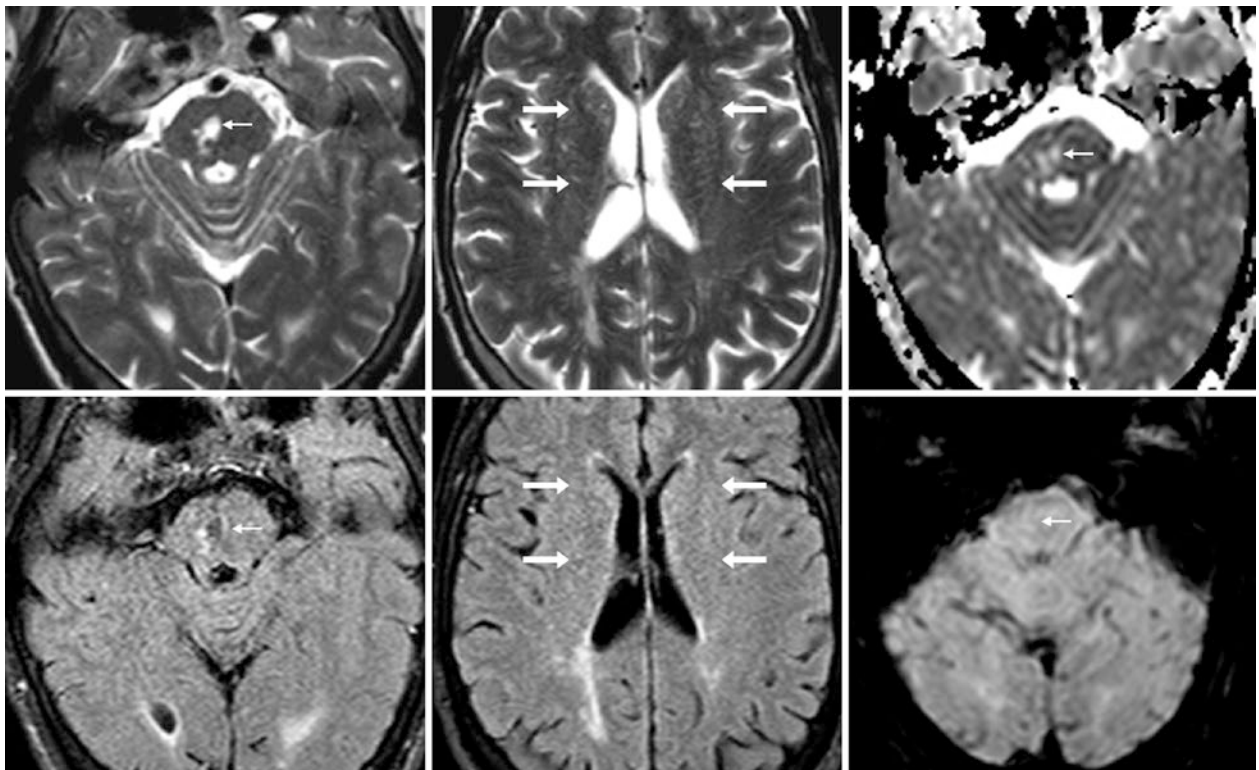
Comparison indeterminate case of an old lacunar infarct versus a dilated PVS. A 57 year old with a cystic lesion (tiny arrows) within the right hemipons on T2WI MRI (top left) had an *état criblé* appearance (arrows) of PVSs within the basal ganglia on T2WI at a higher level (top middle). The brainstem lesion was hyperintense on ADC maps (top right)
